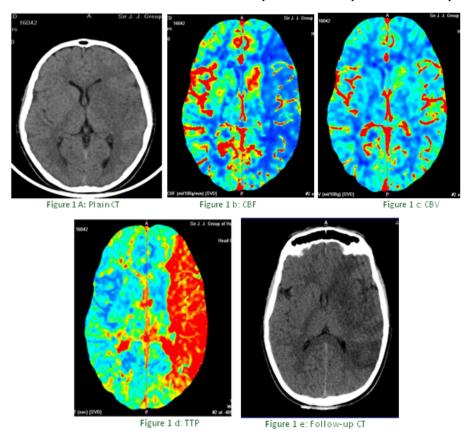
CT Brain images of 18 yrs male with upper motor neuron facial paralysis, aphasia and right upper and lower limb hemiparesis. a. NECT showed obscuration of left lentiform and caudate nucleus with subtle hypodensity. b, c, d. Perfusion CT images showed a CBF-CBV mismatch and delay in TTP in the posterior parietal and temporo-occipital territory of MCA. e. Follow up NECT showed infarct almost equal to mismatch. (CBF=Cerebral blood flow; CBV=Cerebral blood volume; TTP=Time to peak)
